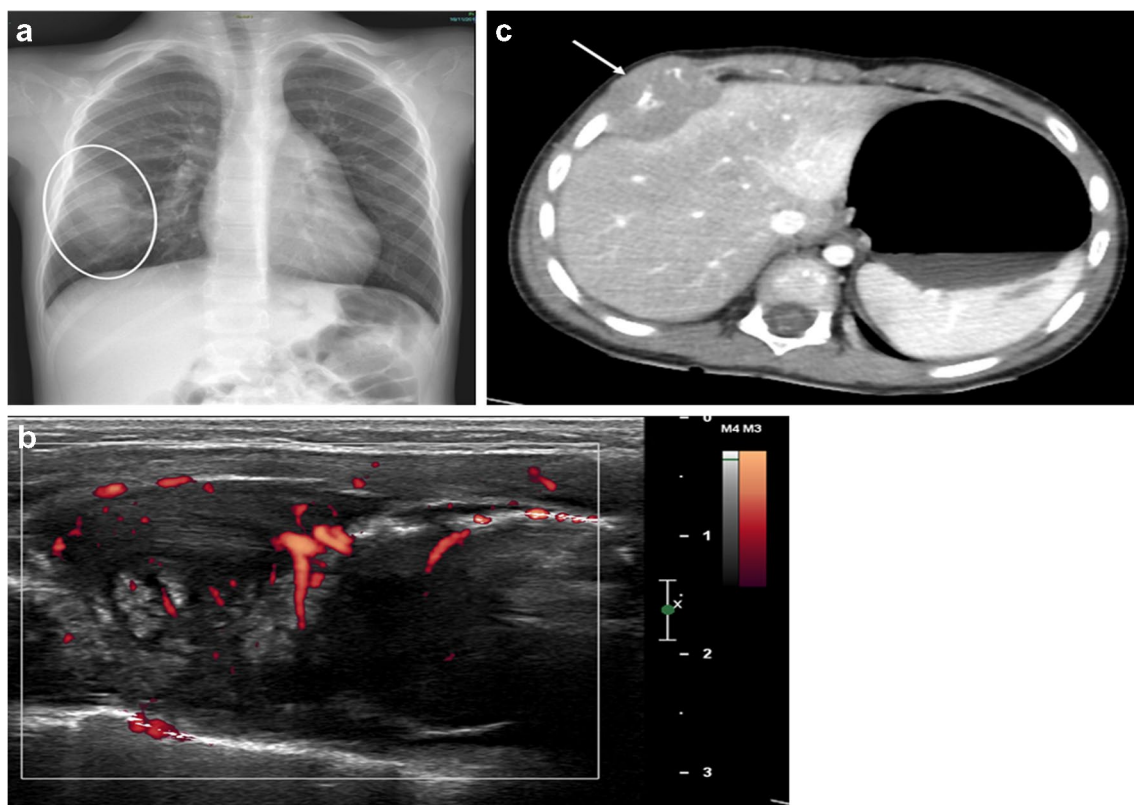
Images of a 5-year-old boy with chest pain and palpable mass at the right lower anterior chest wall. Chest X-rays, posteroanterior view (a) shows a thoracic radio-opacity (*oval line*) involving the anterior arch of the fifth right rib. Ultrasound with power Doppler shows an inhomogeneous neoplasm with rich internal vascularization (b).
